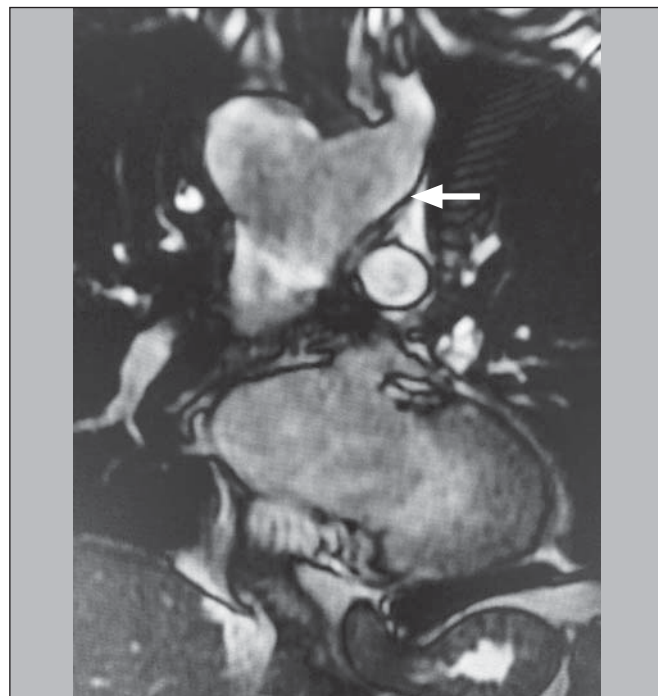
A,B: Axial T2-weighted spin-echo magnetic resonance imaging showing right aortic arch (arrow).
